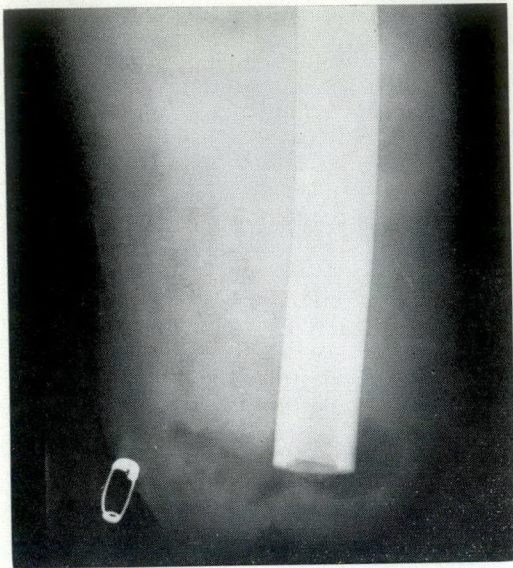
Clostridium welchii* abscess localized to A.K. amputation stump four days postoperatively. Note the localized area of gas on radiograph.
